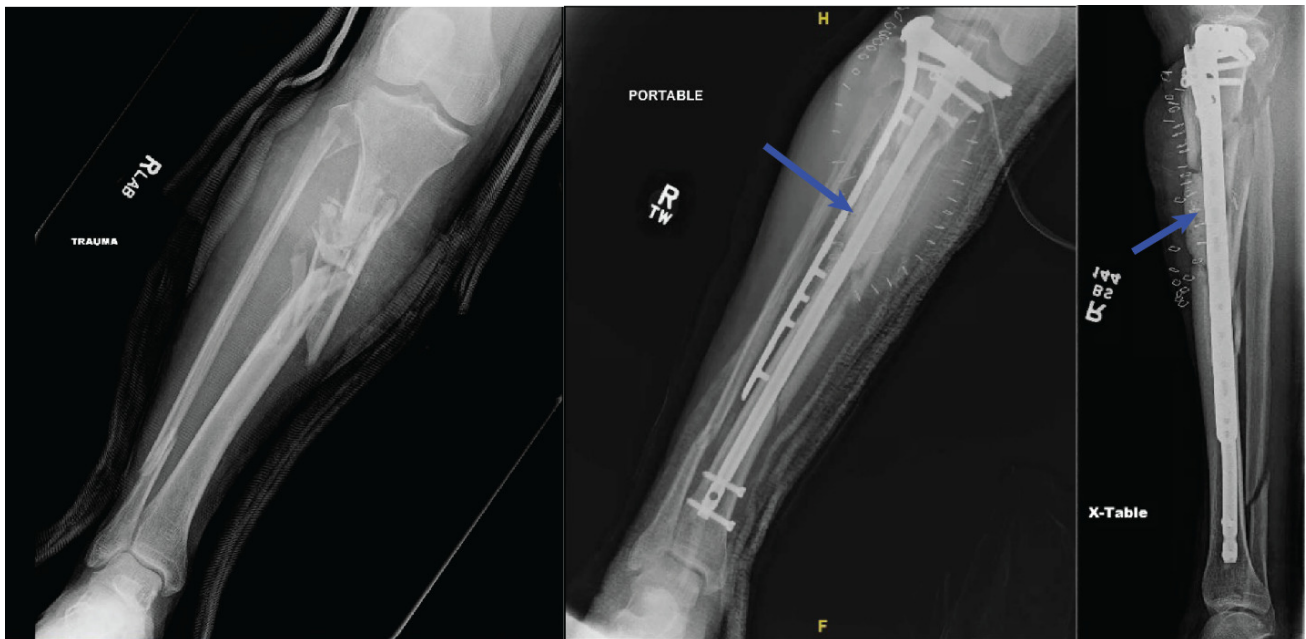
Anterior posterior and lateral radiographs of comminuted right tibia shaft fracture and fibula shaft fracture, status post open reduction and internal fixation and intramedullary nailing with a large osseous defect filled with antibiotic cement using the Masquelet Technique.
